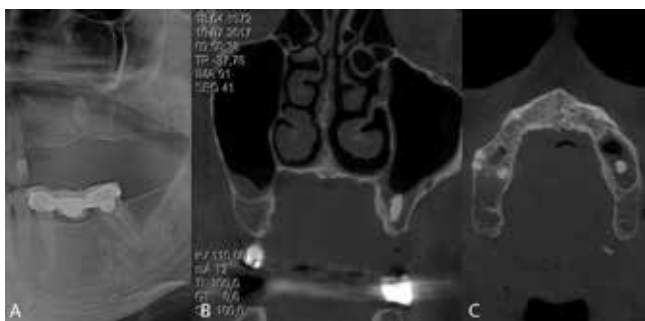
A. Panoramic radiograph showing tooth root displaced into the maxillary sinus. B. CBCT scan demonstrating the displacement of the tooth root into the maxillary sinus, coronal view. C. CBCT scan demonstrating the displacement of the tooth root into the maxillary sinus, axial view.
